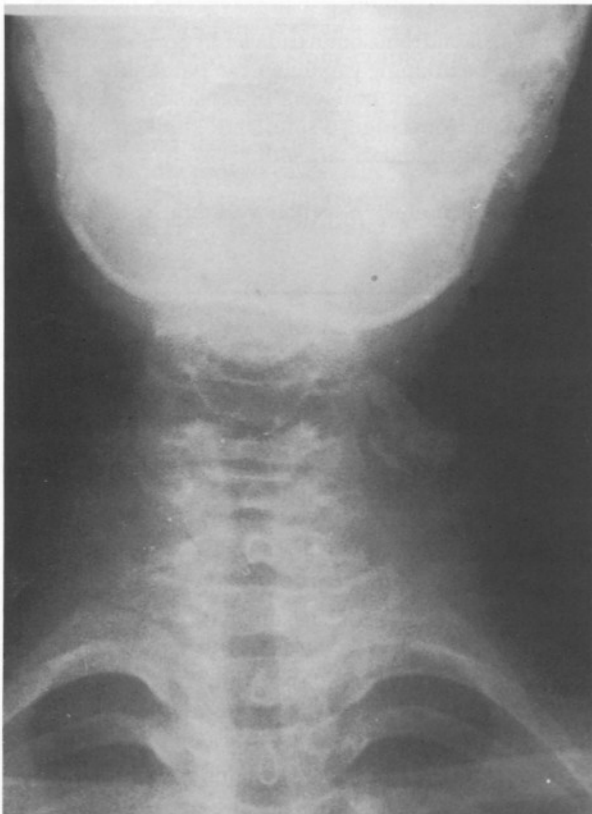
An anteroposterior view on a plain x-ray of the cervical spine demonstrates a mass lesion lateral to the transverse process of the C5 vertebra.
